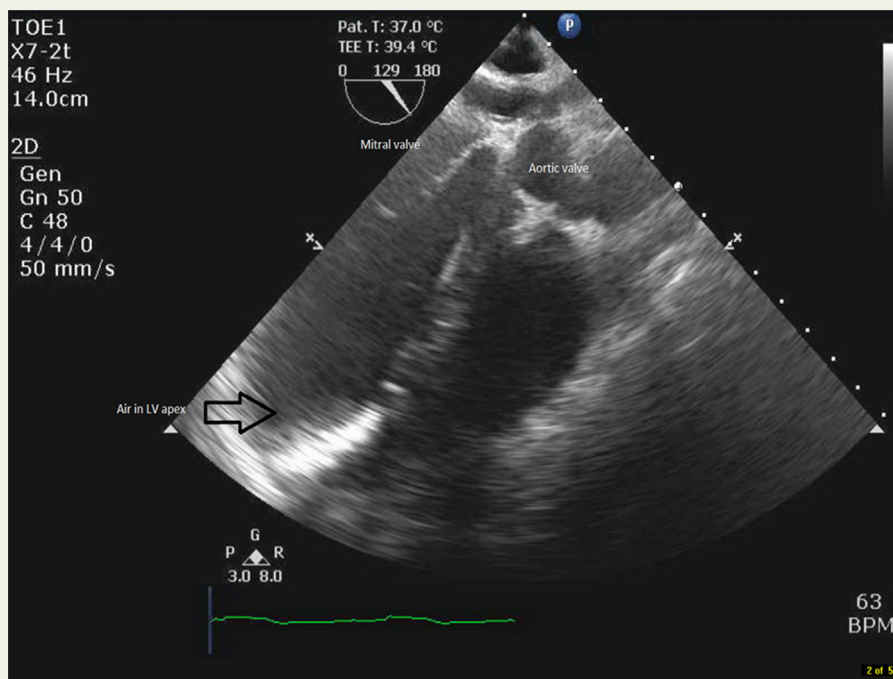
Transoesophageal echocardiogram demonstrating air in left ventricle apex.
